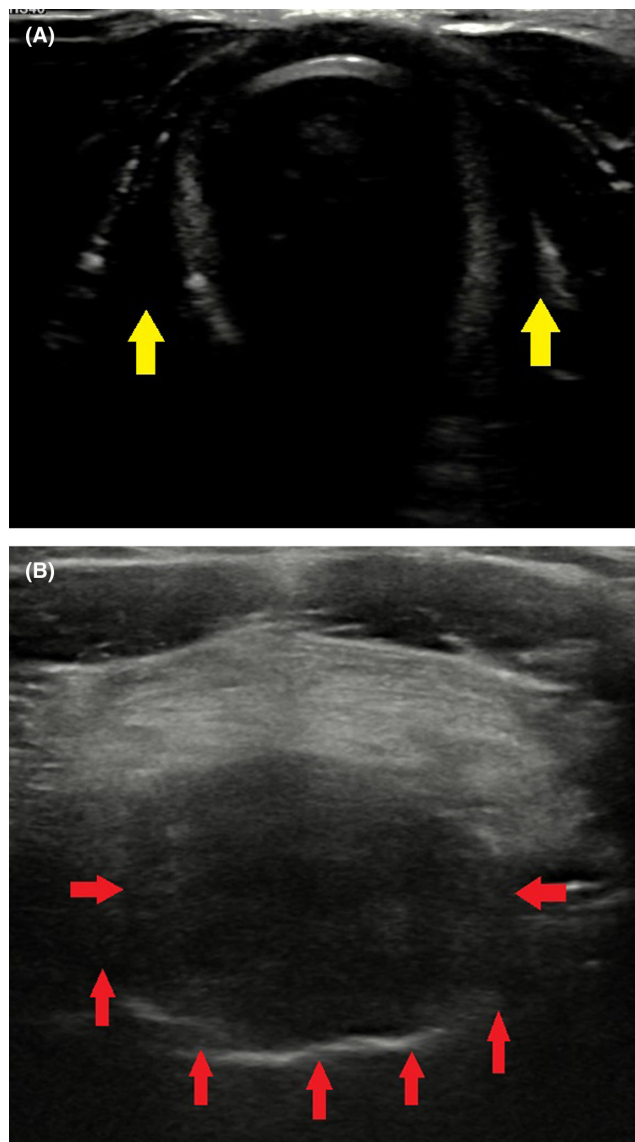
(A) Ultrasonography images of the neck at the expected anatomical location of the thyroid gland (yellow arrows). The thyroid gland is not visualized. (B) A soft tissue structure is visualized in the suprahyoid location, abutting the floor of the mouth (red arrows). The echotexture of the soft tissue structure is mildly heterogeneous.
